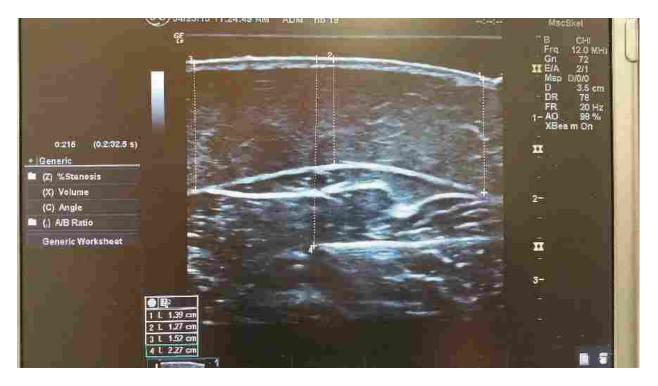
Verification of probe depth insertion via Doppler ultrasound imaging
